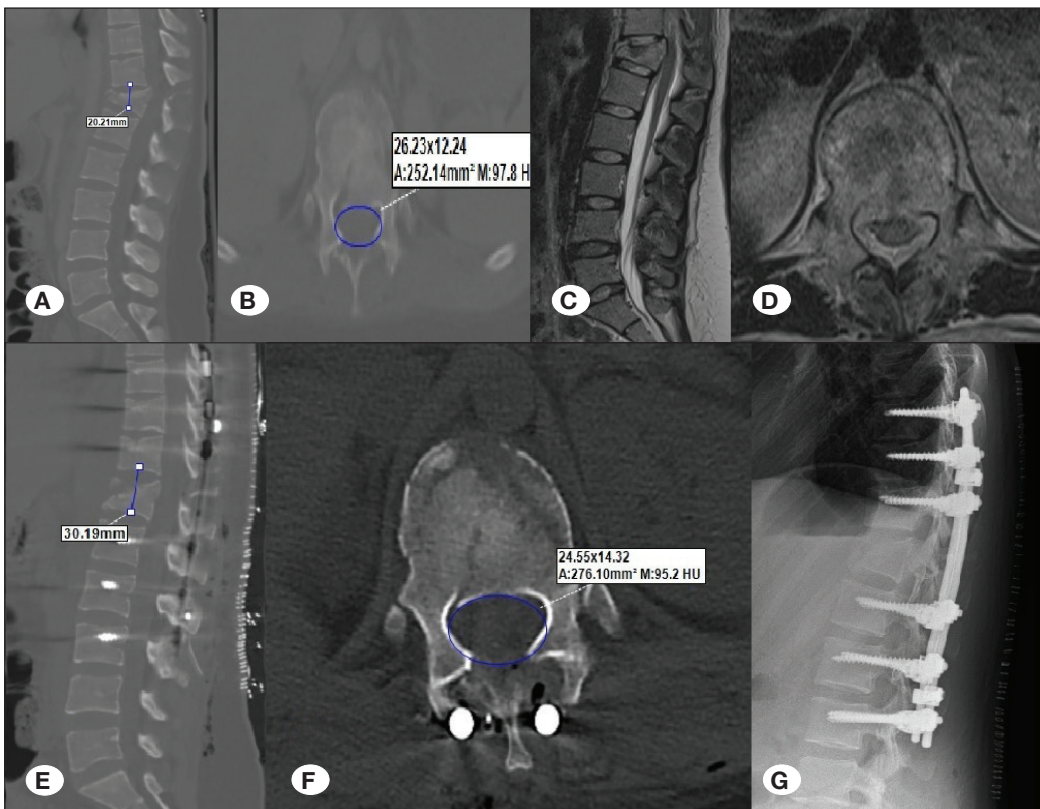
Preoperative sagittal (A) and axial (B) computed tomography (CT) scans and T2W sagittal (C) and axial (D) magnetic resonance imaging of T12 burst fracture with kyphotic angulation. Postoperative sagittal (E) and axial (F) CT images after distraction and ligamentotaxis showing kyphosis correction and expansion of spinal canal. Postoperative directradiography (G) after posterior instrumentation was performed. The distance from the T11 inferior end plate to the T12 inferior end plate increased from 20.21 mm to 30.19 mm (+9.98 mm) (A,E), and the spinal cord occlusion reduced from 31% to 20% (+11%) (B,F).
